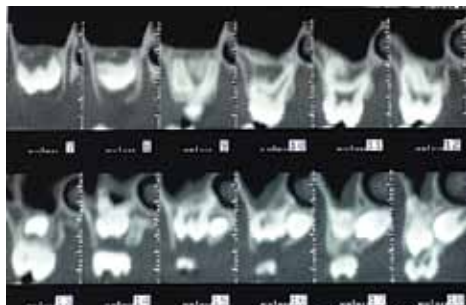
2B Radiographic examination (CT scan and orthopantomogram x-ray).
